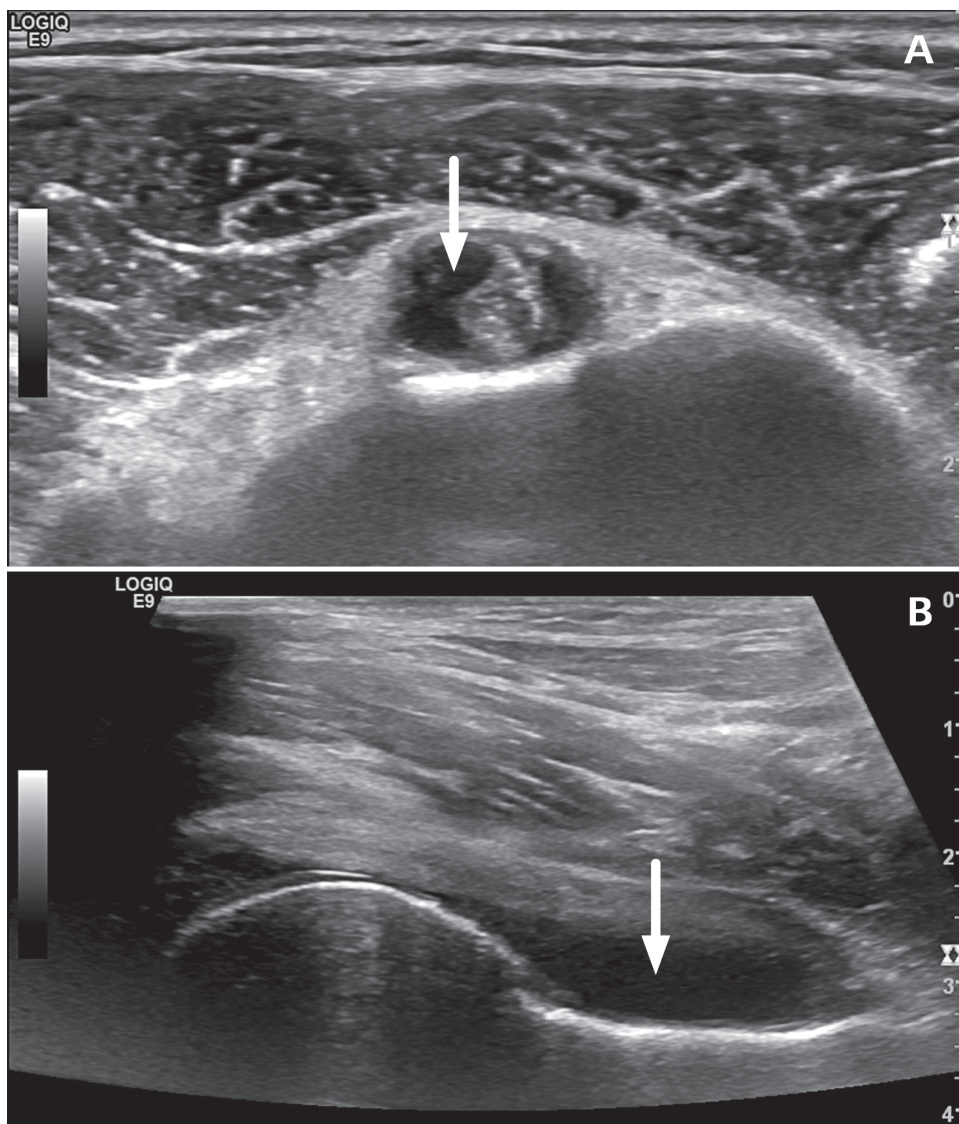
Representative musculoskeletal ultrasound scans. A. Ventral transversal scan of the shoulder joint showing tenosynovitis of the long biceps tendon (arrow). B. Ventral longitudinal scan of the hip joint showing an effusion with distinct capsule distension (arrow).
